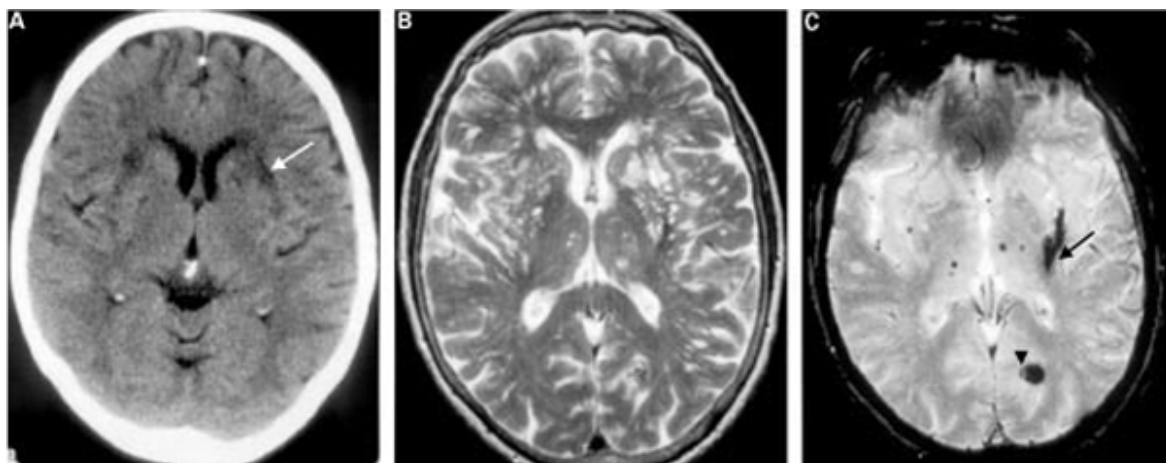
Brain imaging from a 75 year old woman presenting six weeks after a left hemisphere stroke. (A) CT scan. (B) Fast spin echo T₂ MR scan. (C) Gradient echo MR scan. Note on the CT scan (A) the lucent areas consistent
